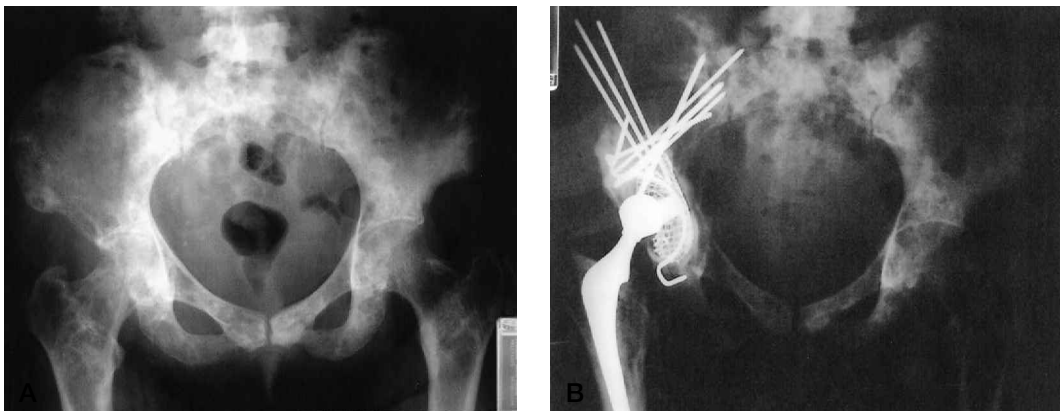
A latticework of Steinmann pins transmitting load-bearing stresses to intact bone in patient with a class III lesion. (A) Preoperative and (B) postoperative radiographs.
